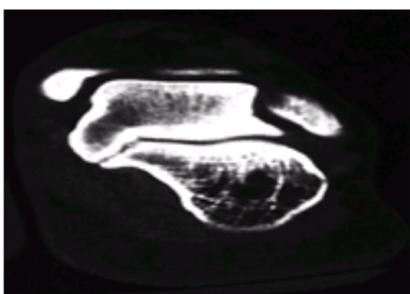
Talocalcaneal coalitions are best seen on computed tomography scans taken in the coronal plane. The middle facet is narrow, irregular, and down-sloping. (From ref. [244](#), with permission.)
